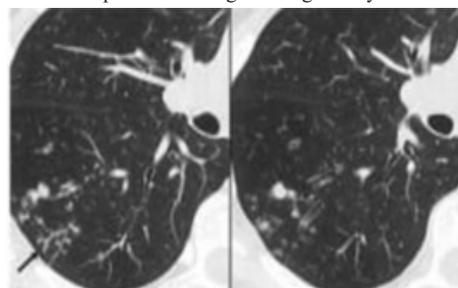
HRCT Thorax showing tree in bud appearance.
